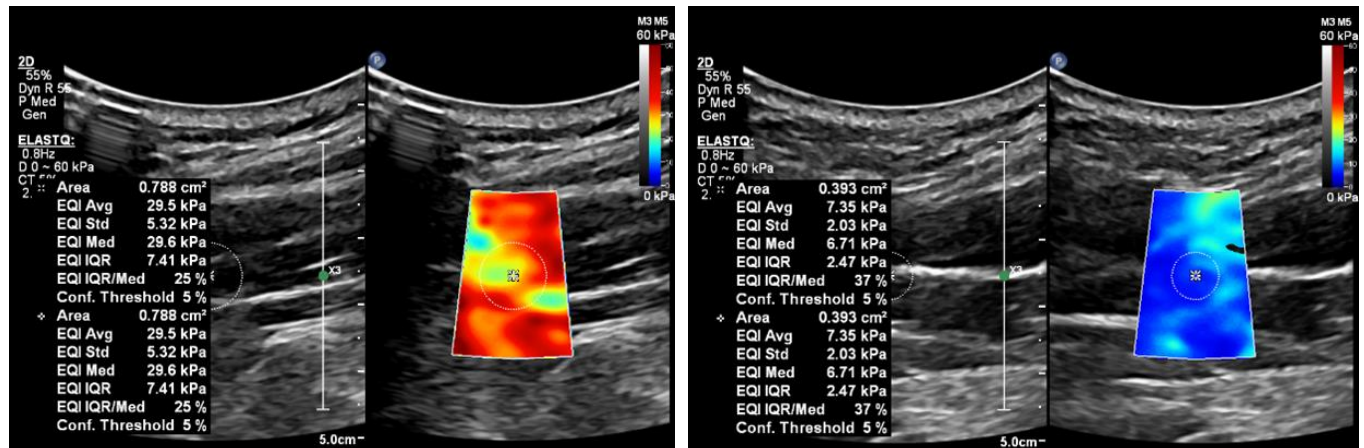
Muscle Ultrasound. Left: trapezius under contraction. Right: Same muscle relaxed. kPa: kilopascal.
